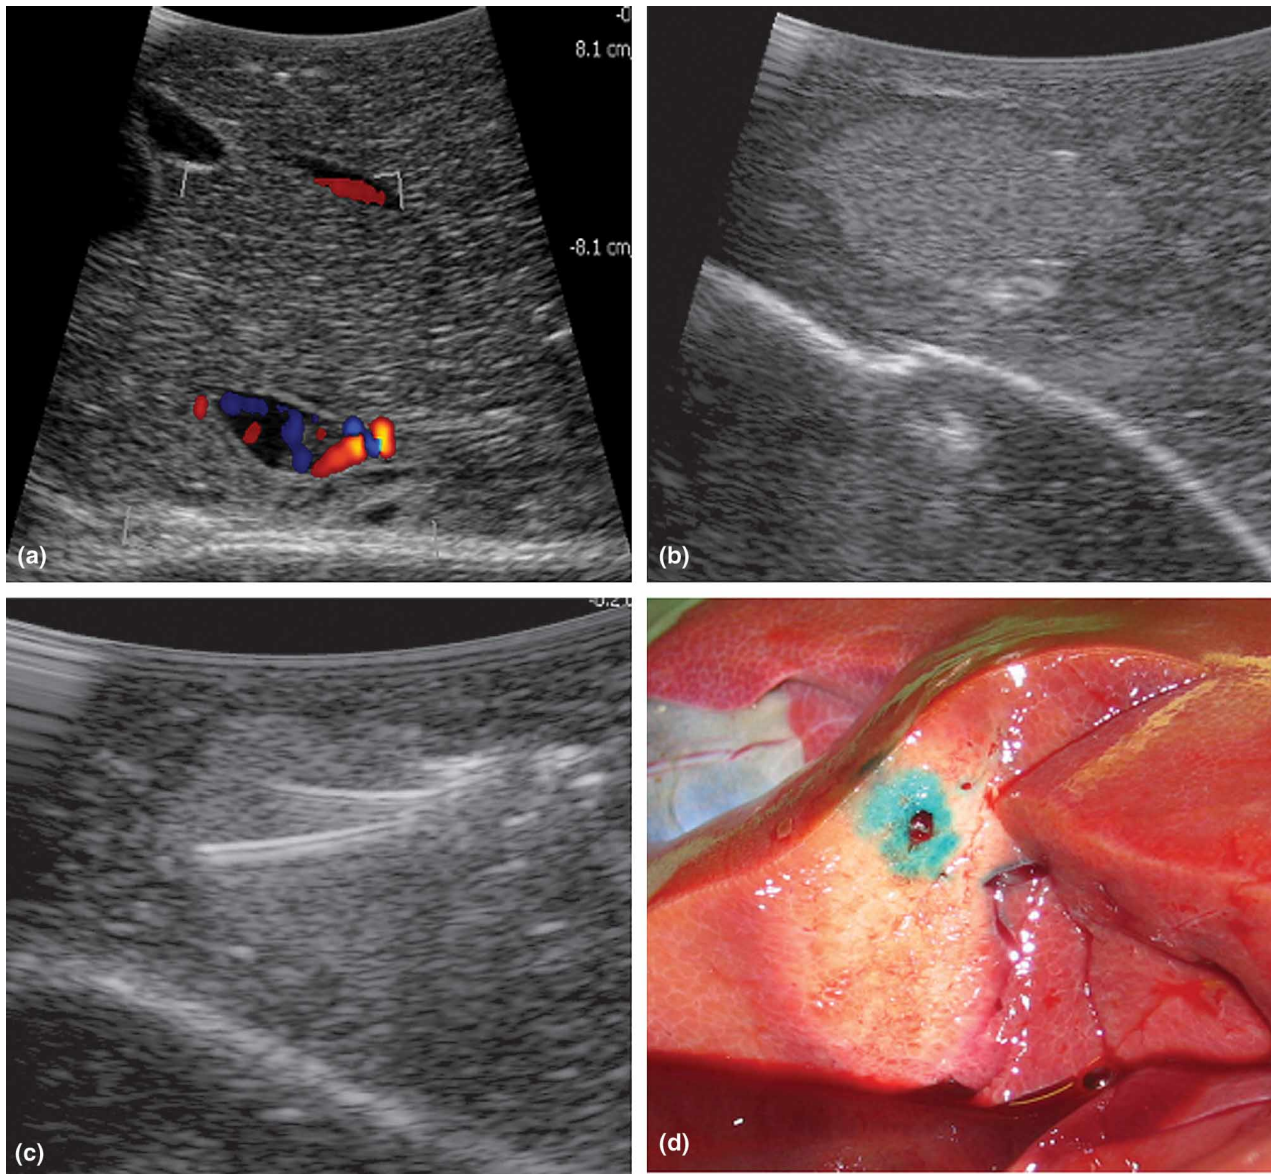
Ultrasound view with color duplex signals (a), hyperechoic artificial tumor (b), and placement of the RFA probe (c). Macroscopic section of a tumor mimic ablation (d).
